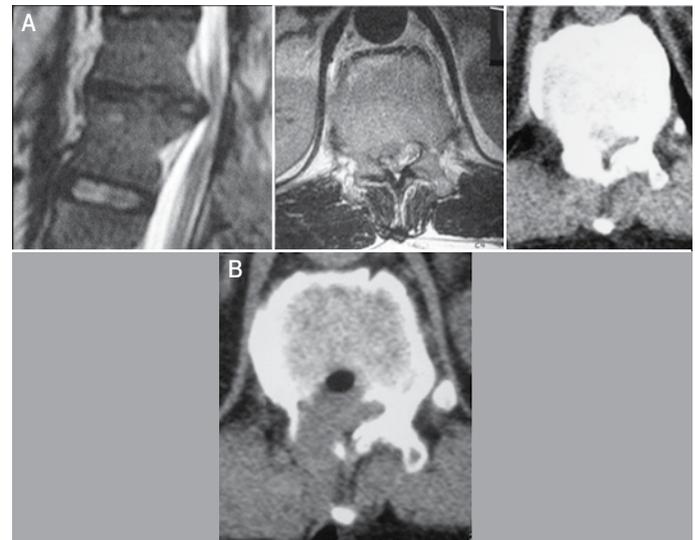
Preoperative imaging shows a calcified central hernia, predominantly in the lateral portion. Postoperative CT shows complete removal via the posterolateral approach (Patient 1 in Table 1).
